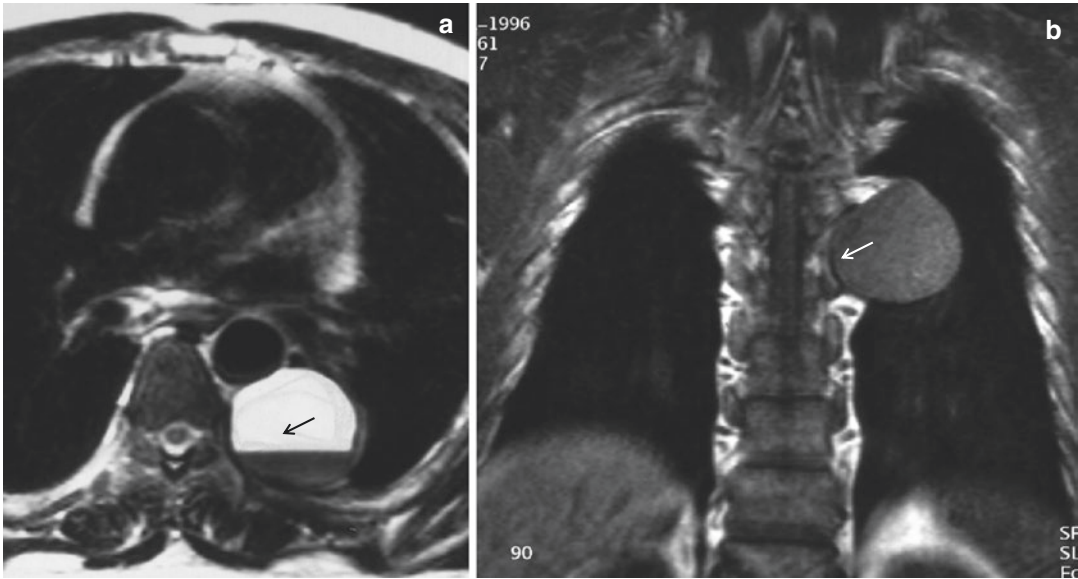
Schwannoma with cystic degeneration. (a) T2-weighted axial image shows a well-defined mass in the paravertebral region. A fluid-fluid level is seen within the mass
